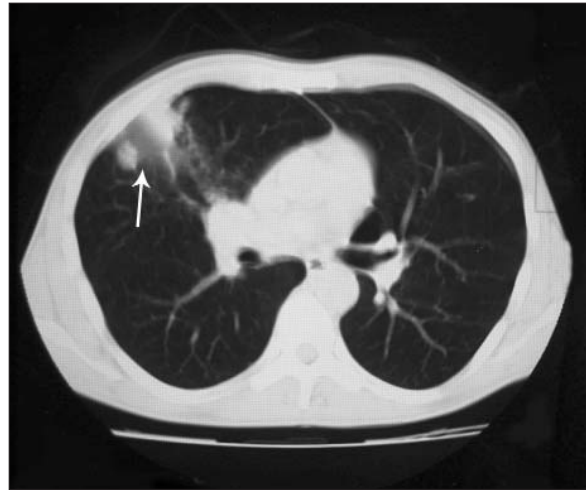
CT image showing a mass lesion in the upper lobe of the right lung.
